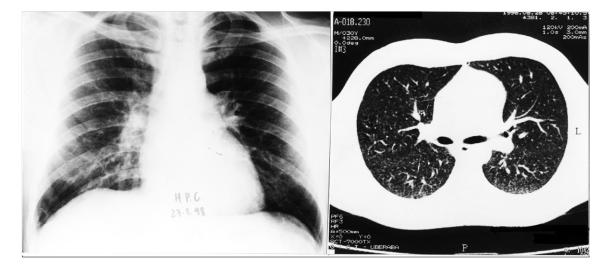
Case 2 control chest x-ray and CT showing only a very discrete micronodular infiltrate.
